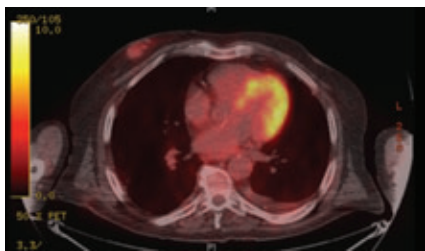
PET scan showing the right retroareolar breast mass with SUV of 2.8 that was discovered while the patient was being treated for his NSCLC of the lung.
